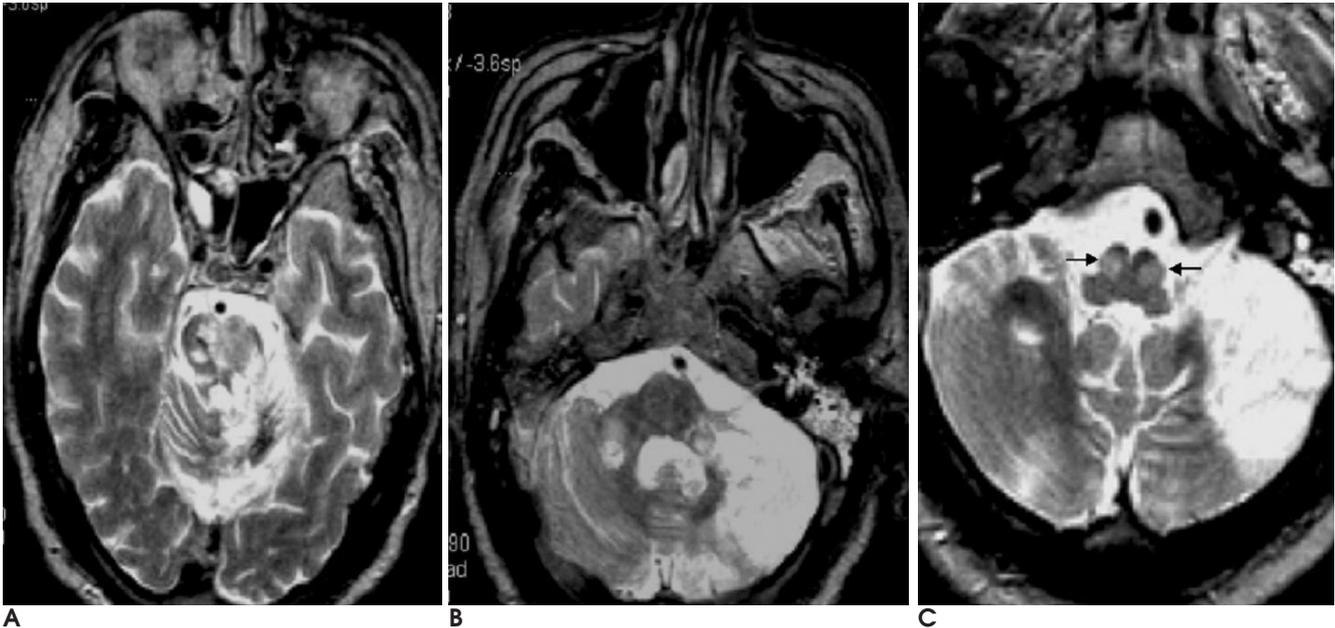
After 4 months later. A. T2-weighted axial image shows high signal intensity at brainstem, more widespread in extent. B. T2-weighted axial image shows high signal intensity at right dentate nucleus, and left cerebellum. C. T2-weighted axial image shows bilateral high signal intensity and hypertrophy in both inferior olivary nucleus (arrow).
